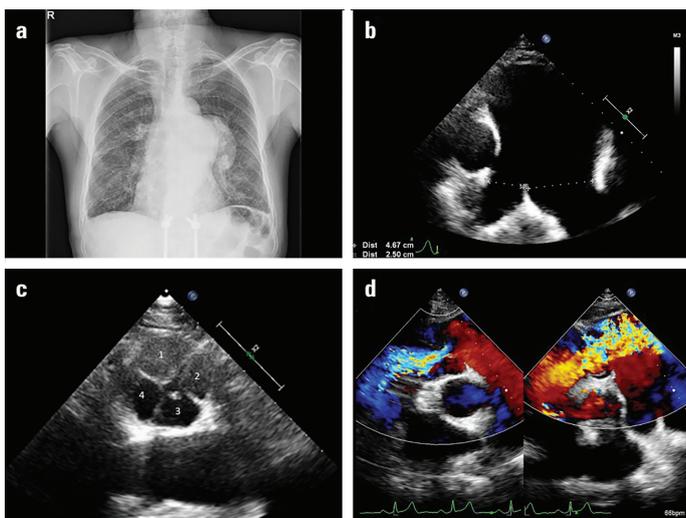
Chest X-ray revealed an enlarged contour of the vessel below the aortopulmonary window (a). Transthoracic echocardiographic image revealed aneurysmal dilation of pulmonary artery trunk and left pulmonary artery (b). A short view of pulmonary valve obtained by transthoracic echocardiography showed a quadricuspid pulmonary valve (c). Color Doppler flow imaging demonstrated the moderate pulmonary insufficiency and systolic flow acceleration (d)
